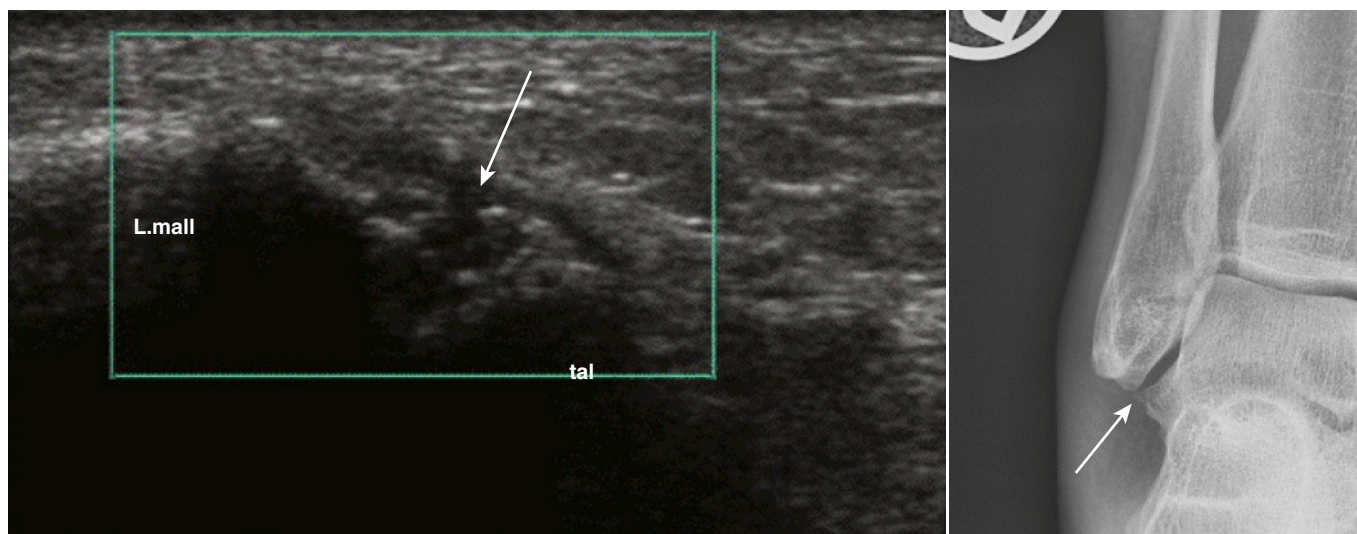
Ultrasound of a torn anterior talofibular ligament (*arrow*) with a correlative radiograph, showing overlying swelling and an irregular talus (*arrow*). L.mall, lateral malleolus; tal, talus.
